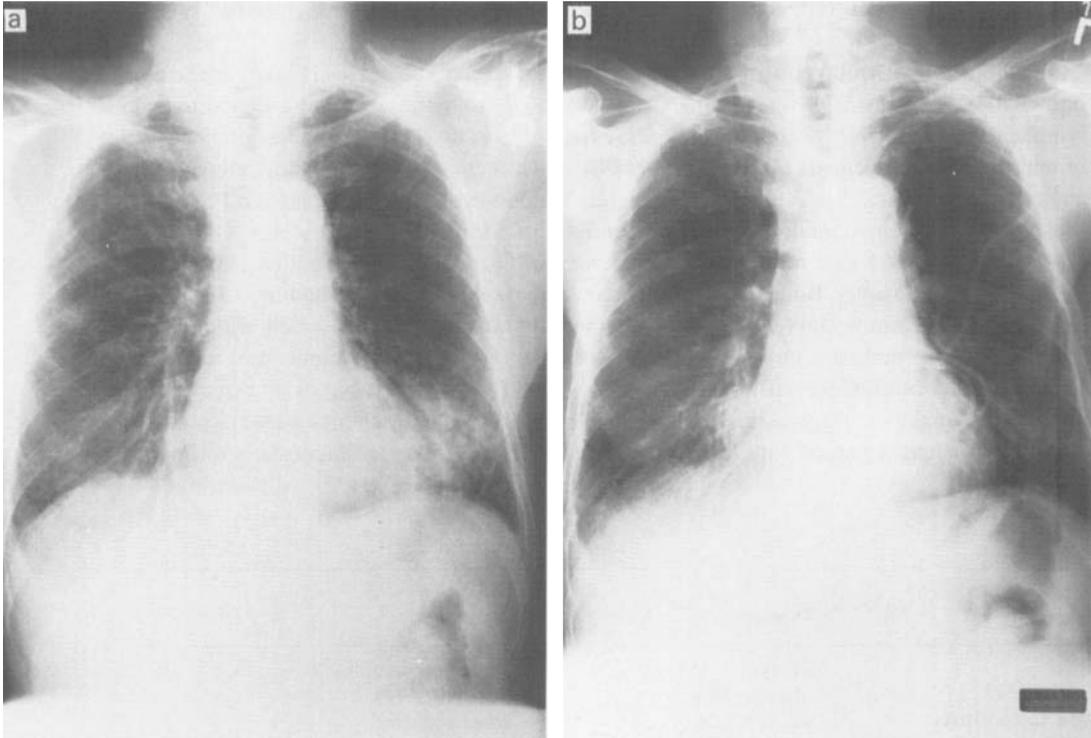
Postero-anterior X-ray films of the chest: (a) before therapy; (b) during amphotericin B therapy (total dose, 20 mg/kg body weight) with Hickman catheter in place.
